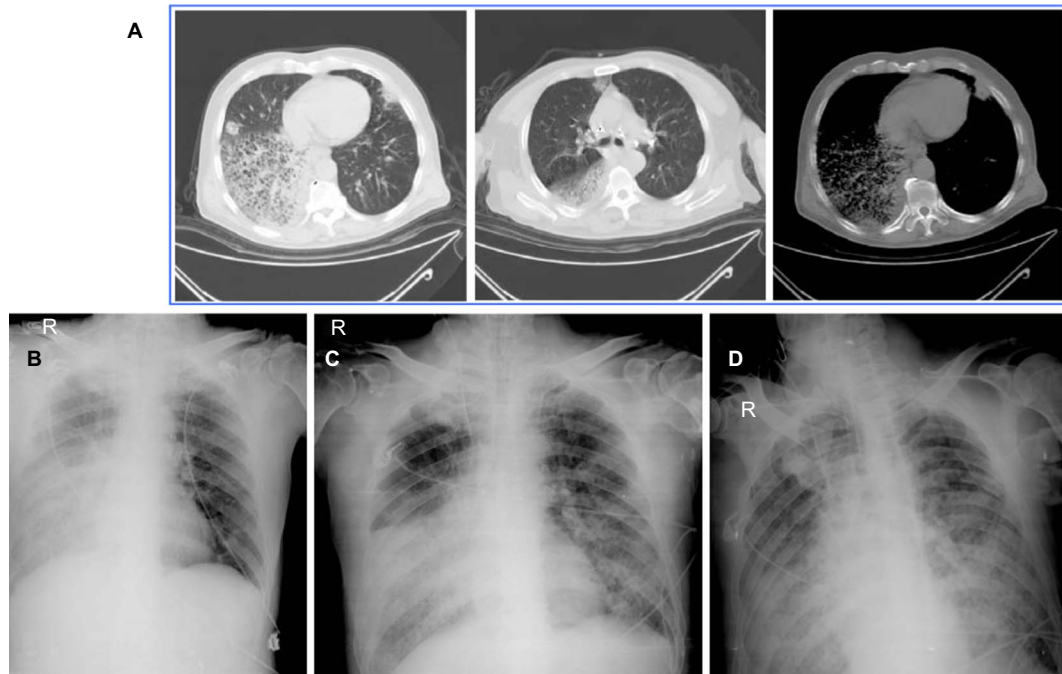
Chest radiographs. Computed tomographic scans of the chest of the patient on March 31st (panel A); Chest X-rays on April 1st–3rd (panels B–D, respectively).
